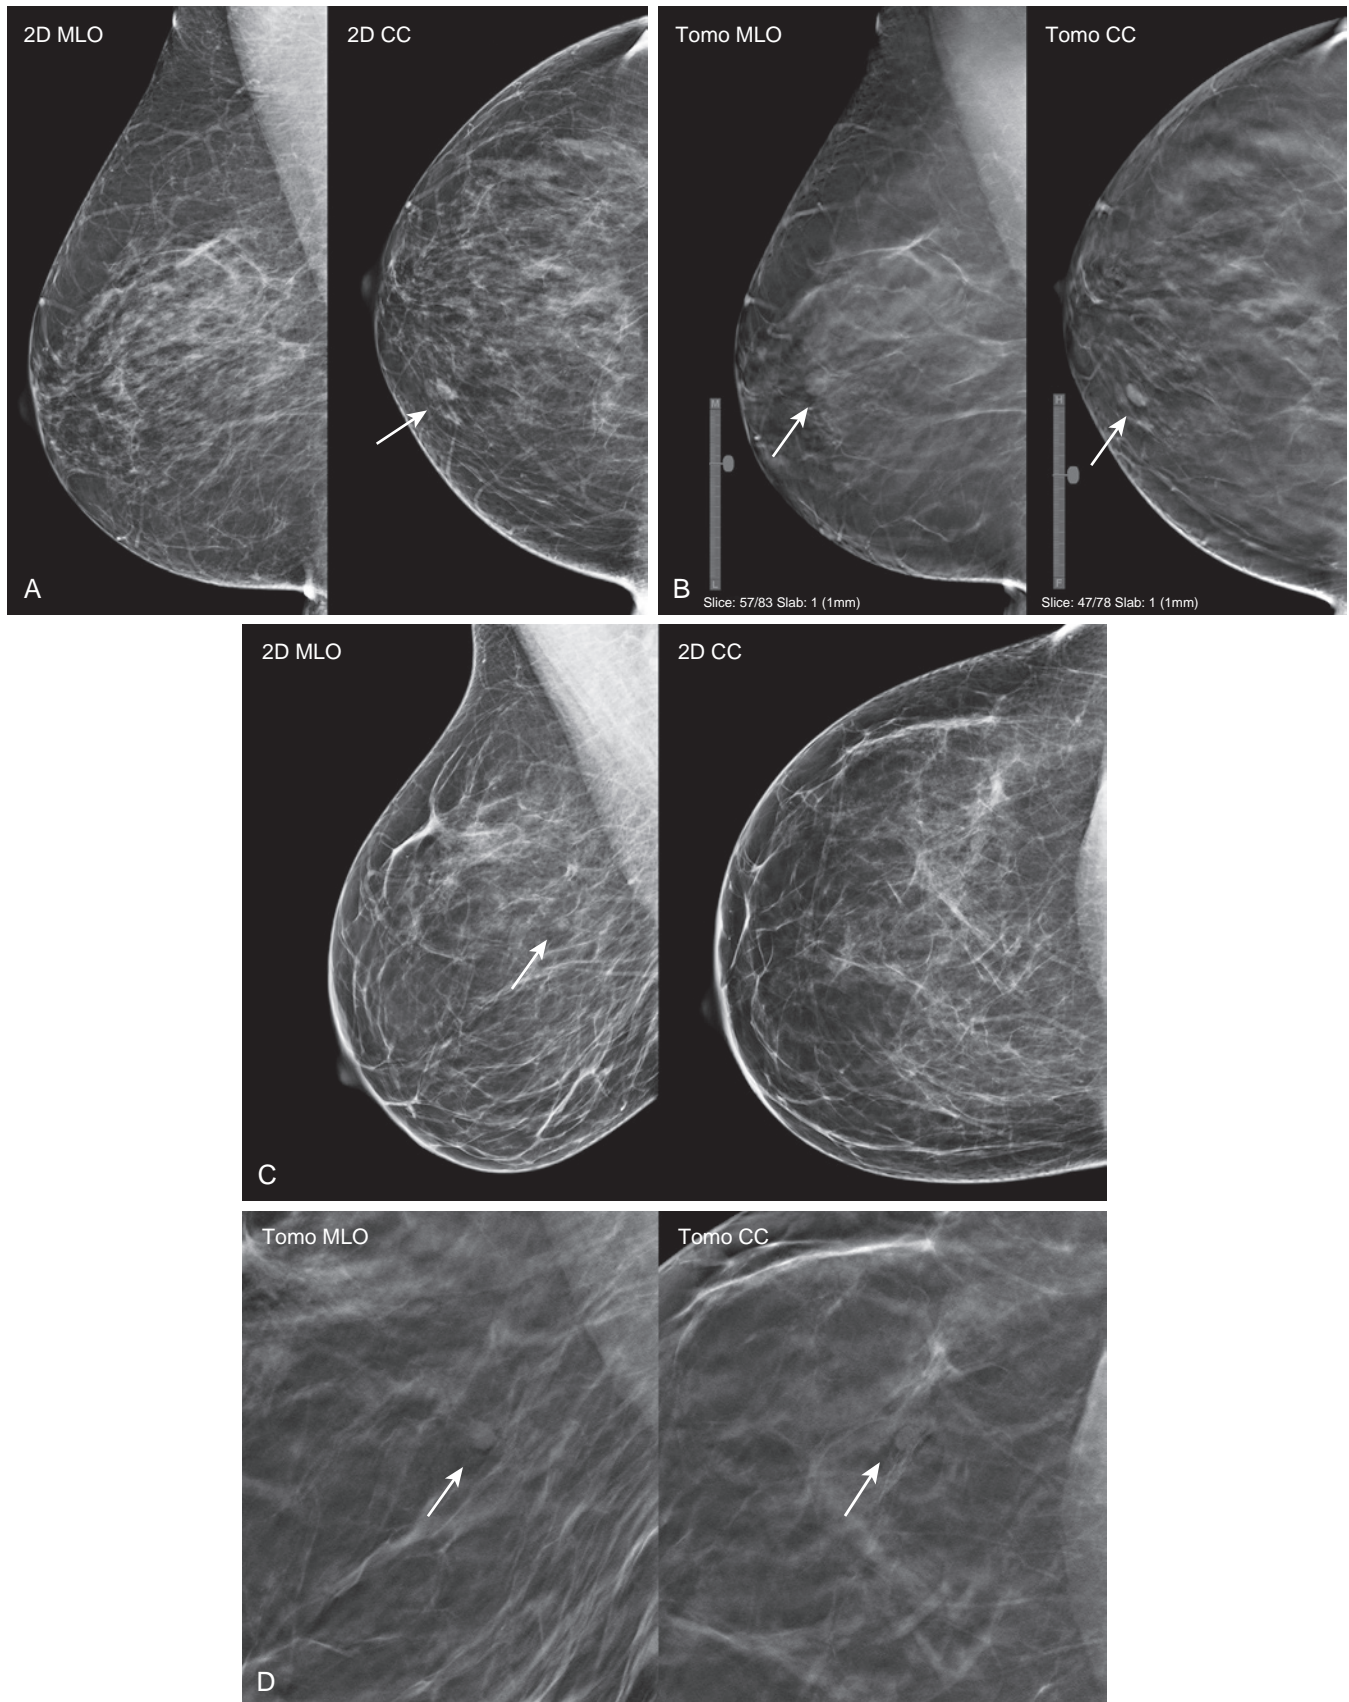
One-view 2D findings seen in both views on tomosynthesis. (A) Screening mammogram in a 64-year-old woman shows a focal asymmetry in the right breast (*arrow*) evident on the 2D CC view only. (B) On tomosynthesis, 2D asymmetry corresponds to a mass (*arrows*) in both the CC and MLO views, permitting more complete assessment of the features and location. Ultrasound (*not shown*) showed a benign lymph node. (C) A 42-year-old woman presented for screening mammography. A small asymmetry (*arrow*) was seen in the right breast on the 2D MLO view only. (D) The close-up tomosynthesis images show the small benign-appearing oval low density mass (*arrows*) clearly in both projections, BI-RADS 2.
